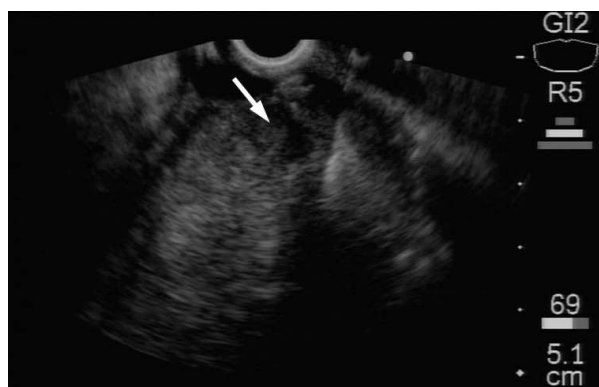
Endoscopic ultrasound of the pancreatic head tumor (arrow).
